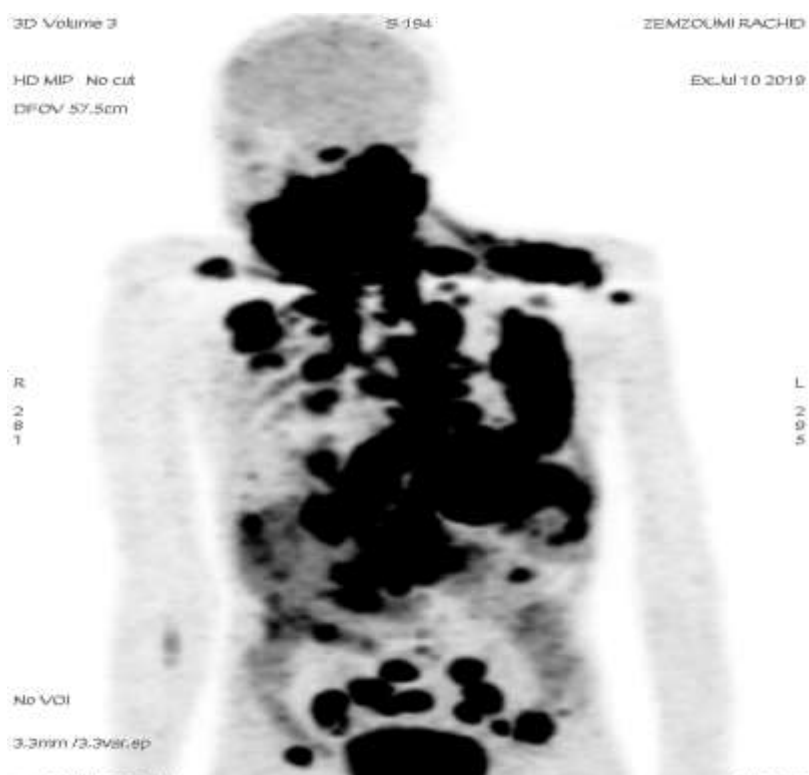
FDG-PET Scan (coronal plane) showing in addition to the left mandibular hypermetabolic mass , supra and sub diaphragmatic lymph nodes hypermetabolism , pulmonary nodules , involvement of the left pleura ,lever ,spleen , bone and bilateral adrenal parenchyma (stage IV).
